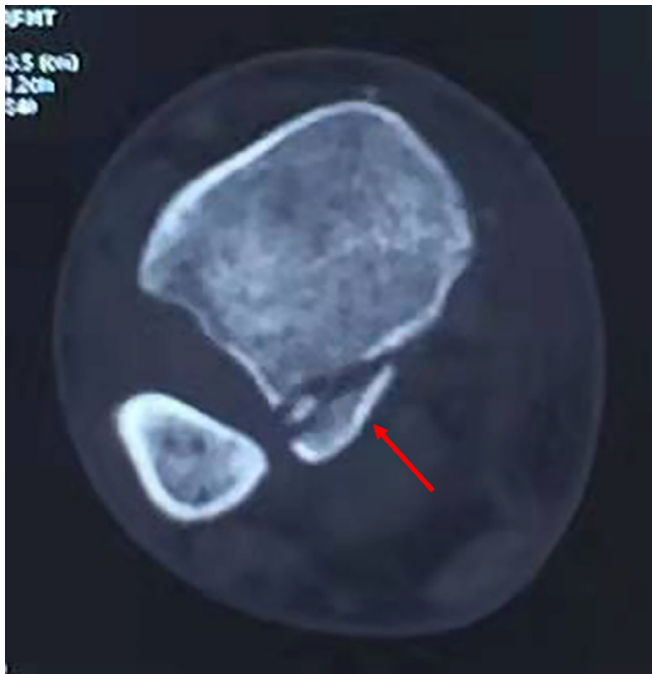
The CT scanning of the ankle joint showing the type I (posterolateral oblique) fracture according to the Haraguchi classification of posterior malleolus fracture (red arrow: type I posterior malleolus fracture)
